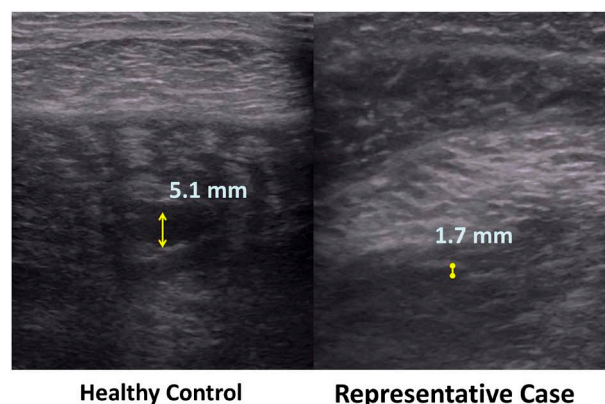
Short axis scan of the left soleal vein of representative case by ultrasonography. The vessel (the diameter of the vessel, 1.7 mm) is smaller compared to that of healthy control (the diameter of the vessel, 5.1 mm).
